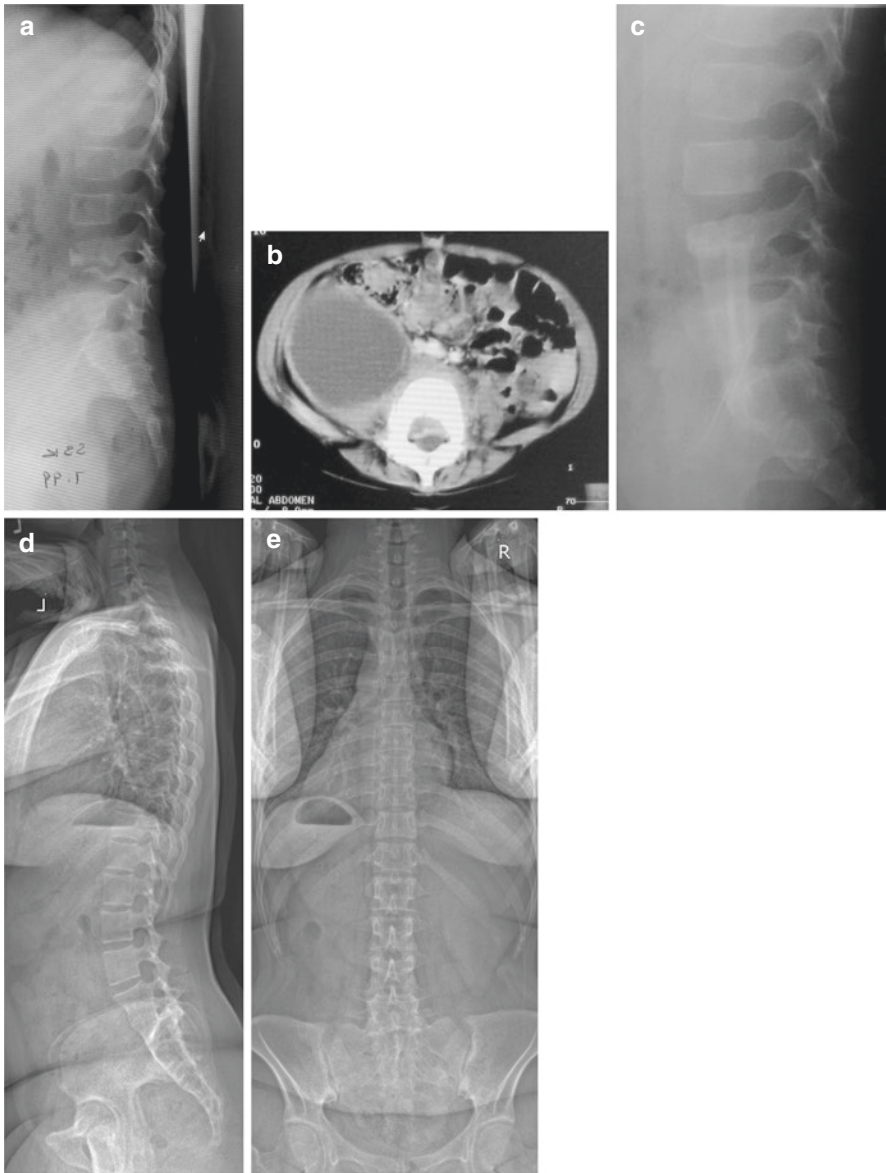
This 6-year-old patient suffered TB spine. (a) Lateral X-ray showing the complete collapse of L5 and partial collapse of L4. (b) Axial CT scan demonstrating a huge right psoas abscess. (c) Lateral X-ray after the anterior debridement and fusion L3 to S1 using a fibular graft. (d, e) Standing whole spine X-ray 20 years after surgery. The global spinal alignment was well maintained
